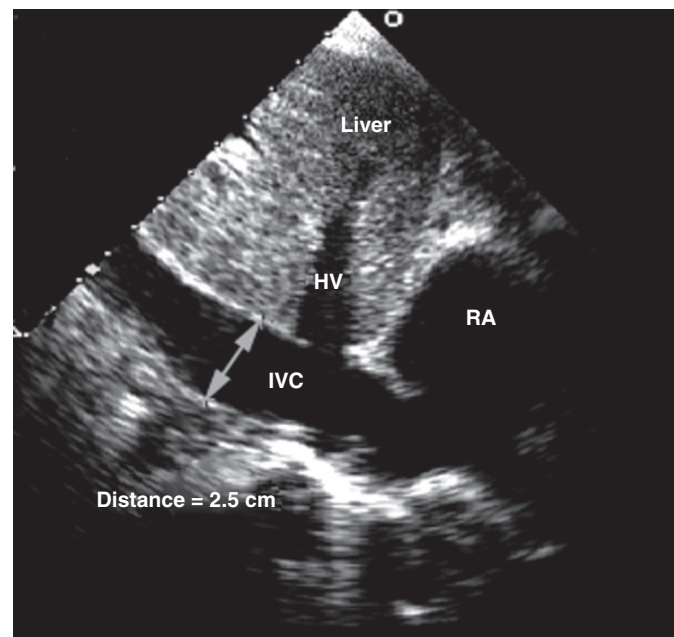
■ Indirect assessment of circulating volume status on two-dimensional echocardiography by assessing the diameter and change in caliber with inspiration of the inferior vena cava (IVC). This method has been shown to discriminate reliably between right atrial pressures of less than or greater than 10 mm Hg. A dilated vena cava (>20 mm) without the normal inspiratory decrease in caliber (>50% on gentle sniffing) usually indicates elevated right atrial pressure. A small vena cava reliably excludes elevated right atrial pressure in these patients. In this case, the IVC was dilated at 2.5 cm with minimal respiratory variation in a patient spontaneously breathing. The right atrial pressure was estimated to be approximately 10 to 15 mm Hg. Images were obtained in the subcostal view. HV, hepatic veins; RA, right atrium.
